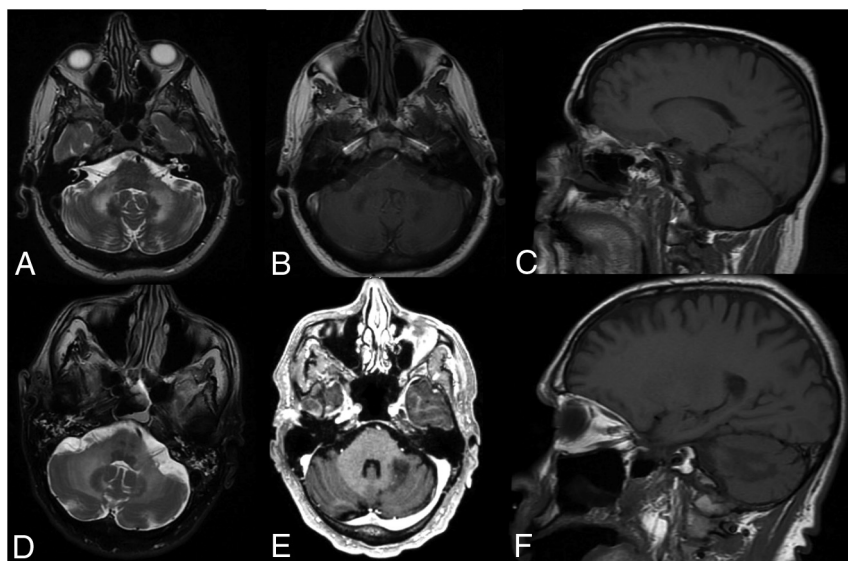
In both cases, brain MR imaging revealed well-defined, T2-hyperintense (patient 1 [A], patient 2 [D]) and T1-hypointense lesions (patient 1 [B and C], patient 2 [E and F]) of the cerebellar white matter abutting and sharply demarcating and outlining the dentate nucleus.
